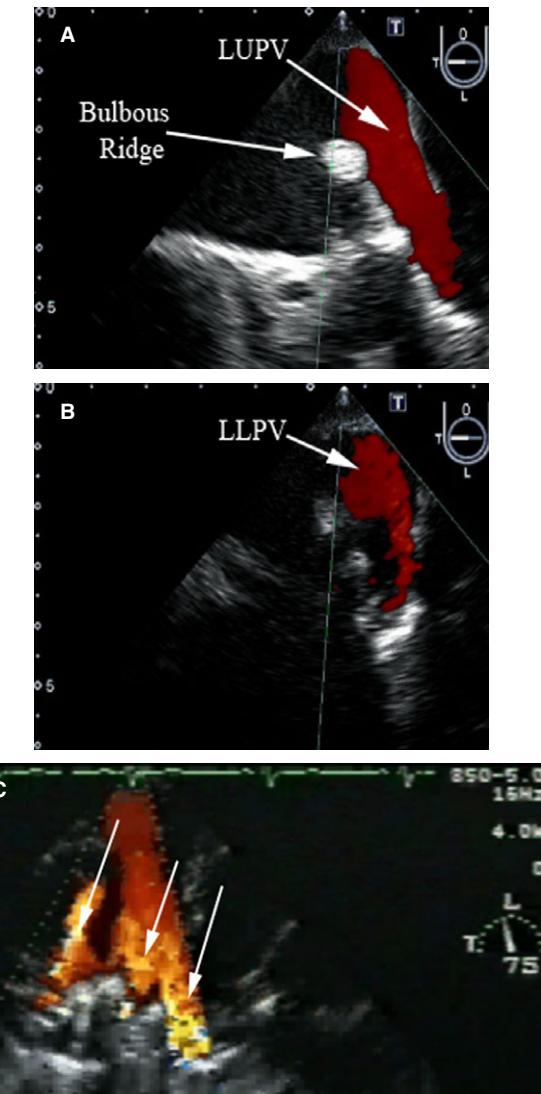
A-C. Transesophageal echocardiography (TEE) with color Doppler for visualization of (A) the LUPV and (B) LLPV. Left PVs generally are best visualized in the mid-esophagus from about 110° – 140° with counterclockwise probe rotation. The LUPV is first visualized with the left atrial appendage (LAA) and bulbous infolding serving as landmarks. Advancing the probe will help bring the LLPV into view. The RPVs are visualized from about 45° – 90° with clockwise probe rotation. With this image (C) there are three separate RPV-LA ostia. LUPV = left upper pulmonary vein.
